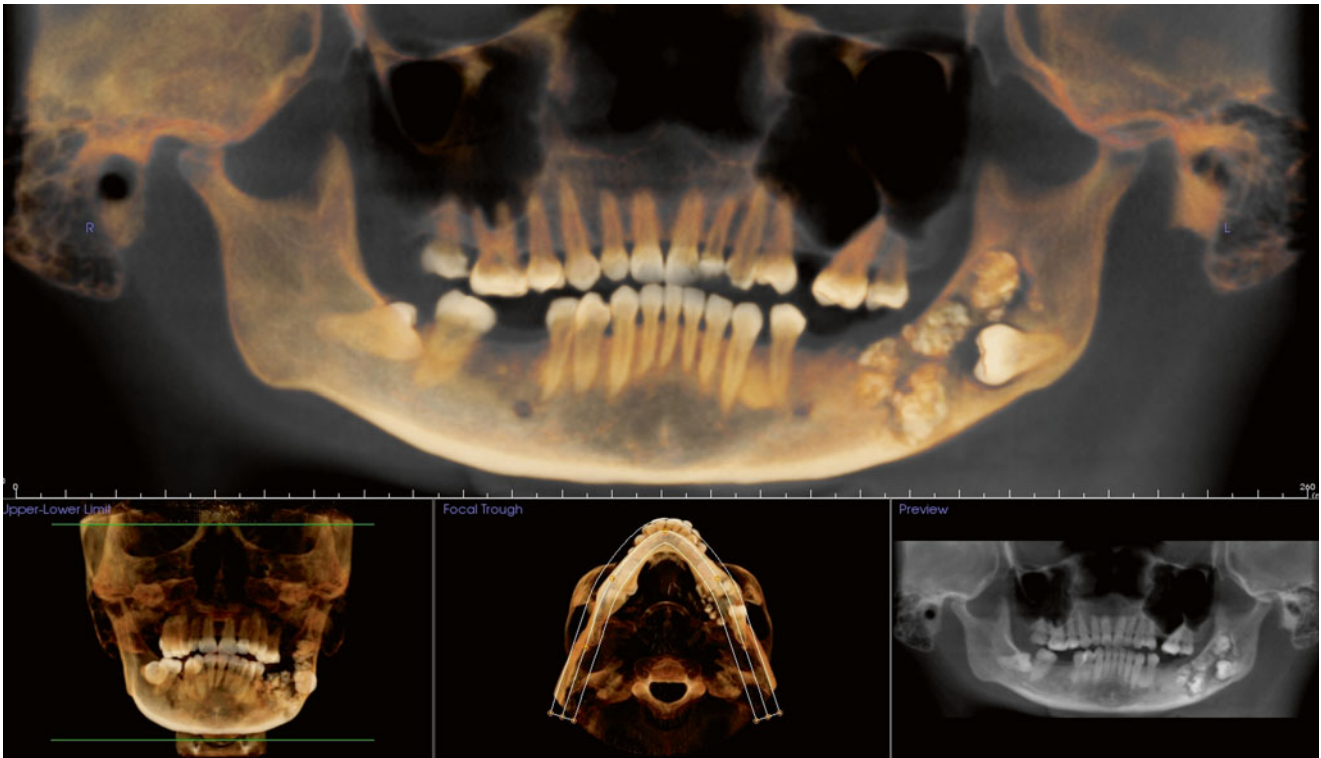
Tumor occupying the left body/ascending ramus of the mandible demonstrated in CBCT three-dimensionally rendered format
